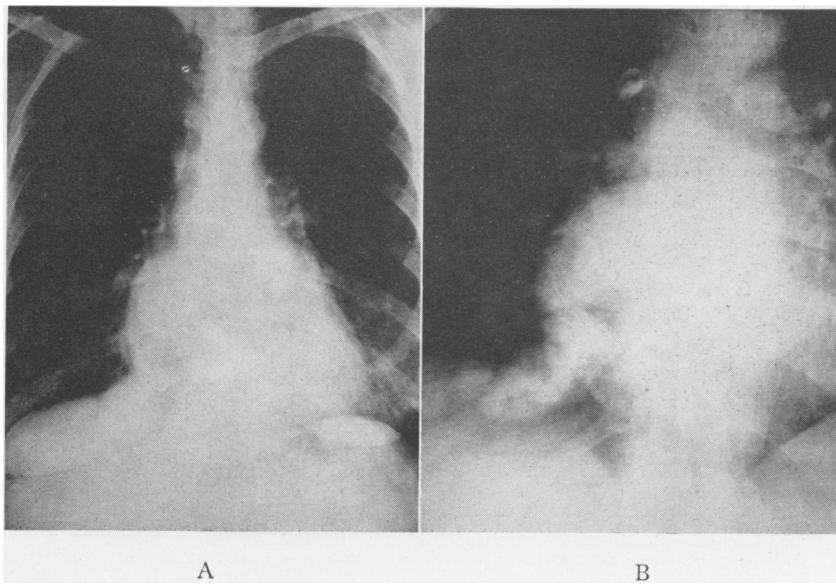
Case 2. (A) P. A. Roentgenogram. (B) Angiocardiogram.
